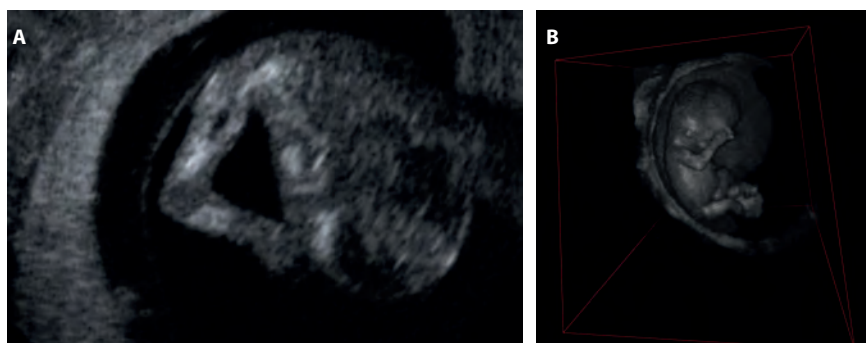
During the second pregnancy of the patient, at 10+6 weeks gestational normal upper extremities with presence of radii were visualized by (A) ultrasonography and (B) virtual reality. This excluded the diagnosis of thrombocytopenia-absent radius syndrome in this pregnancy.
